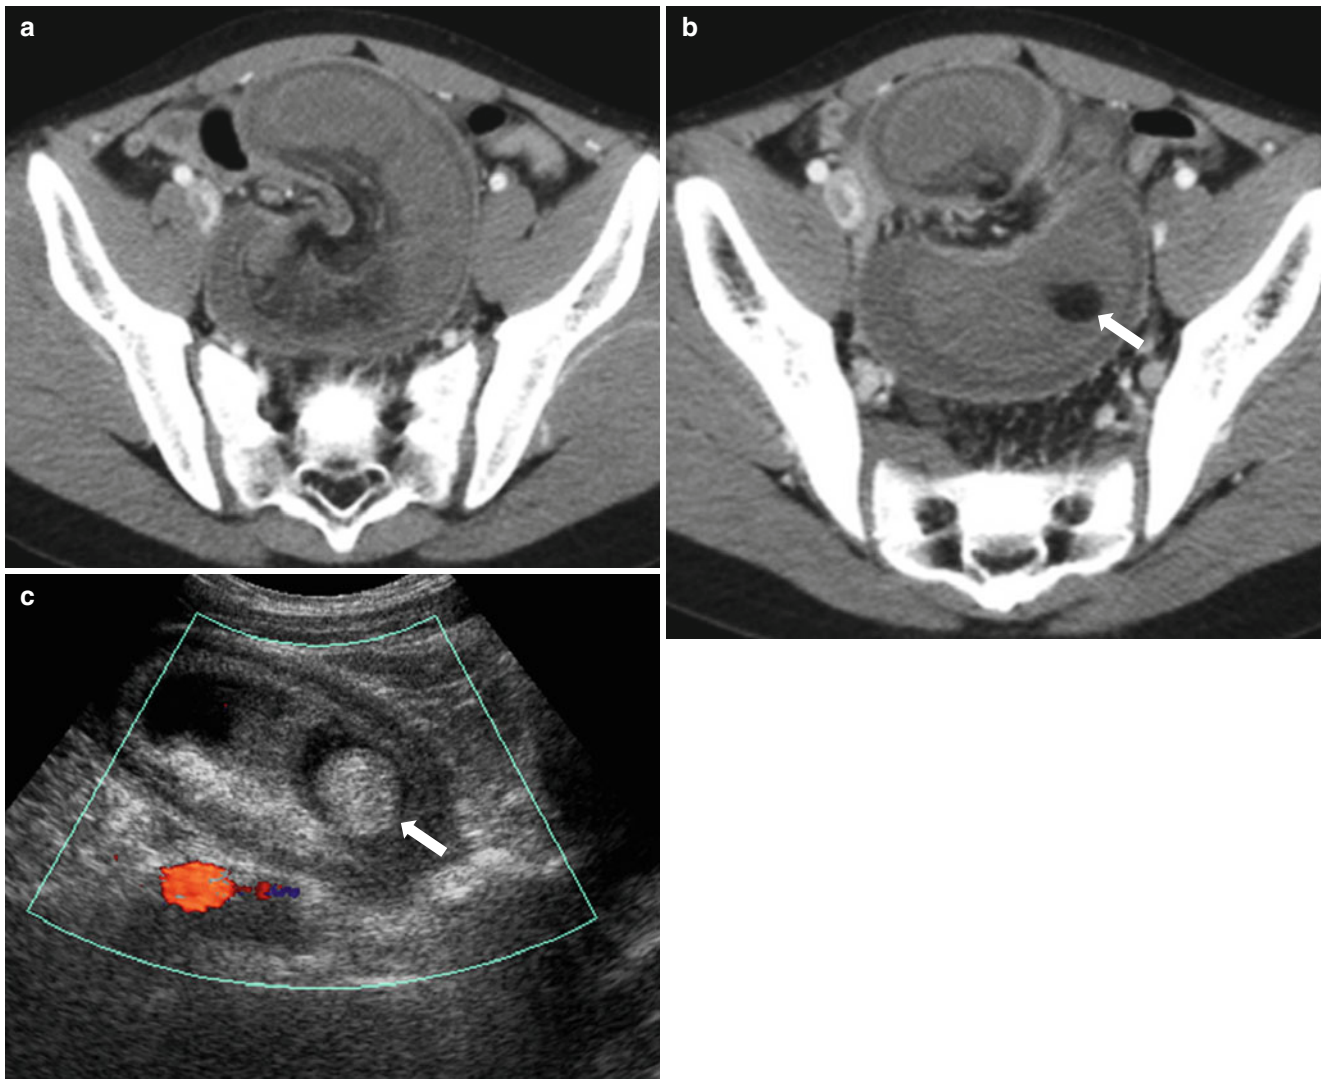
Meckel's diverticulum complicated by intussusception in an 11-year-old boy who presented with abdominal pain developed 3 days earlier. Contrast-enhanced CT images (a, b) reveal a long segmental small-bowel intussusception of which the invaginated bowel shows fluid-filled distension and lack of enhancement of the wall as well as
